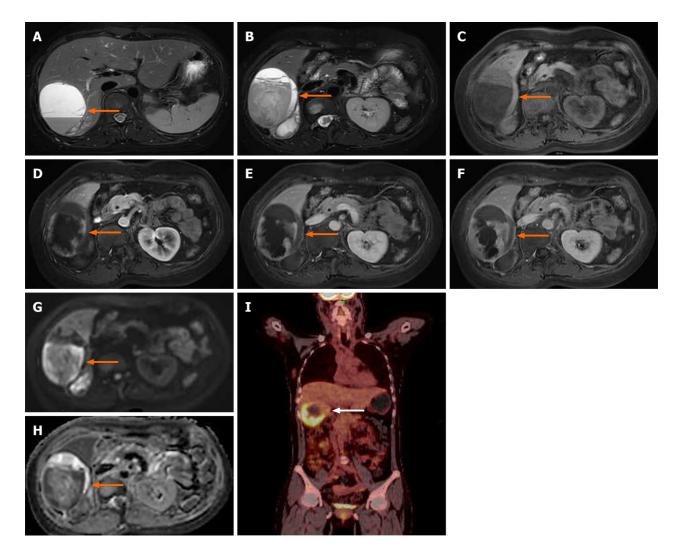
Magnetic resonance imaging of the upper abdomen and positron emission tomography-computed tomography. Magnetic resonance imaging showed a massive abnormal signal lesion in the right lobe of the liver, with septations and fluid levels. The lesion showed heterogeneous hypointensity on T1-weighted imaging and heterogeneous hyperintensity on T2-weighted imaging. The edges and septations of the lesion were significantly enhanced during the arterial phase, and the enhancement partially fused and filled toward the center of the lesion during the portal phase and delayed phase. Diffusion-weighted imaging showed a hyperintense signal and the corresponding apparent diffusion coefficient map showed a decreased signal intensity in parts of the wall of the lesion (the arrow shows the lesion). The positron emission tomography-computed tomography scan showed an irregular low-density lesion in the right lobe of the liver with increased uptake (the arrow shows the lesion). A and B: T2-weighted imaging; C: T1-weighted imaging; D: Diffusion-weighted imaging; E: Apparent diffusion coefficient; F: The arterial phase of the enhanced scan; G: The portal vein phase; H: Delayed phase; I: Positron emission tomography-computed tomography.
